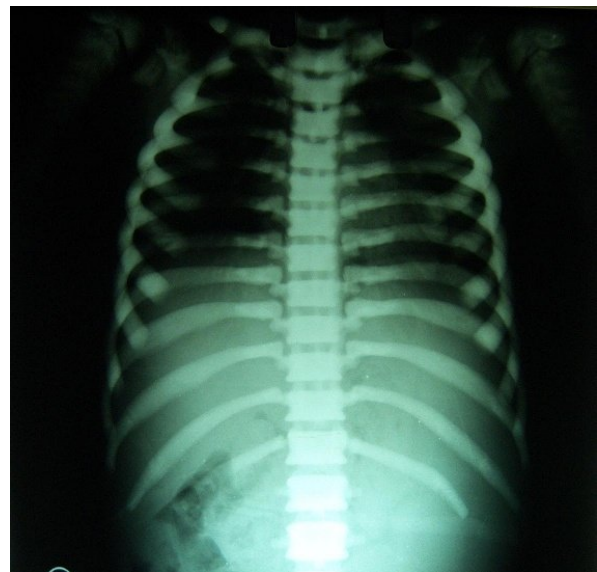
Radiograph of spine (lateral view) showing alternating bands of lucent and dense bands.
